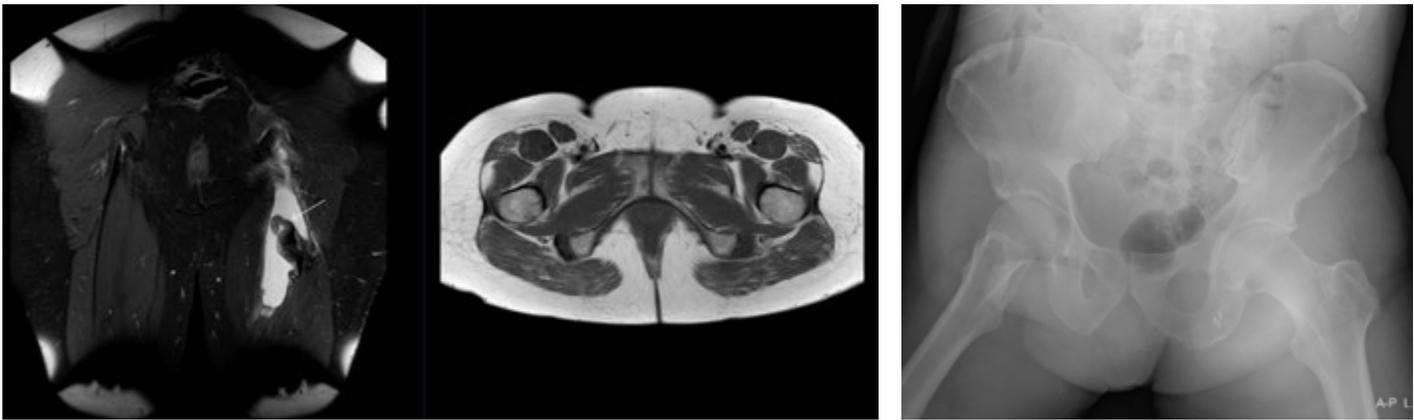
Coronal and axial MRI demonstrating proximal hamstring tendon avulsion on the left side (left), and radiographic evaluation of correct positioning of suture anchors follow surgical repair (right).
